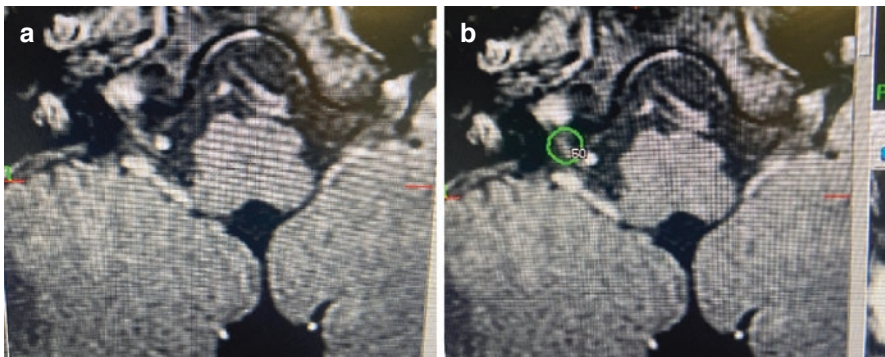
This is a 22-year-old man with autism who is nonverbal. For the past year, he had experienced what seemed to be sudden severe episodes of pain in the right ear that lasted a few minutes and then would go away. Ear exam was normal. The pain was initially better on gabapentin, but he now had to increase his dose 3600 mg/day and was still having episodes of pain. He also still had pain episodes when carbamazepine was added. MRI showed a medium-sized artery contacting the right ninth cranial nerve. Because it was not possible for the patient to confirm the exact nature of his symptoms, it was decided to try a Gamma Knife treatment for presumed right glossopharyngeal neuralgia. Several weeks after Gamma Knife treatment, the patient had no more episodes of pain. (a) MRI axial postcontrast image at time of Gamma Knife treatment, showing a medium-sized artery contacting the right ninth cranial nerve; (b) MRI axial postcontrast image at the time of Gamma Knife treatment with targeting of the ninth nerve
